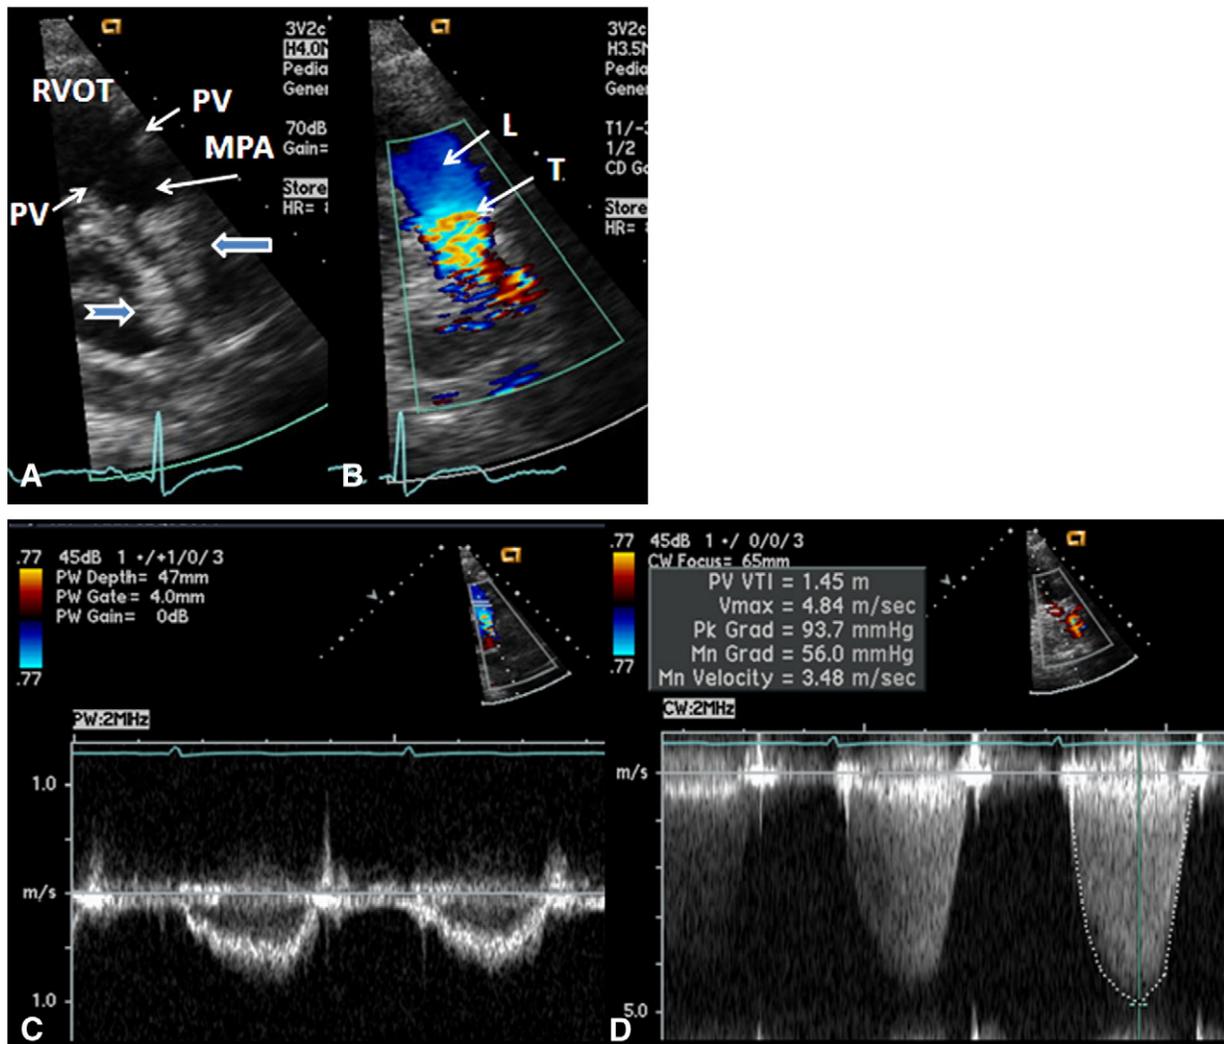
(A) Selected video frame from a precordial short axis view of the heart demonstrating echo dense structures (thick blue arrows) within and outside the main pulmonary artery (MPA). Pulmonary valve (PV) leaflets (small arrows) are shown and appear normal. The right ventricular outflow tract (RVOT) and proximal MPA are free of any echo-dense structures. (B) Color Doppler mapping of the same structures as in panel A shows normal laminar (L) flow in the RVOT and proximal MPA and turbulent (T) flow starting in the MPA, indicating obstruction. (C) Pulse Doppler sampling from the proximal MPA which shows normal flow velocity. (D) Continuous wave Doppler sampling demonstrating high velocity flow across the MPA with a calculated peak instantaneous gradient of 93.7 mmHg and a mean gradient of 56 mmHg, indicating severe obstruction.
